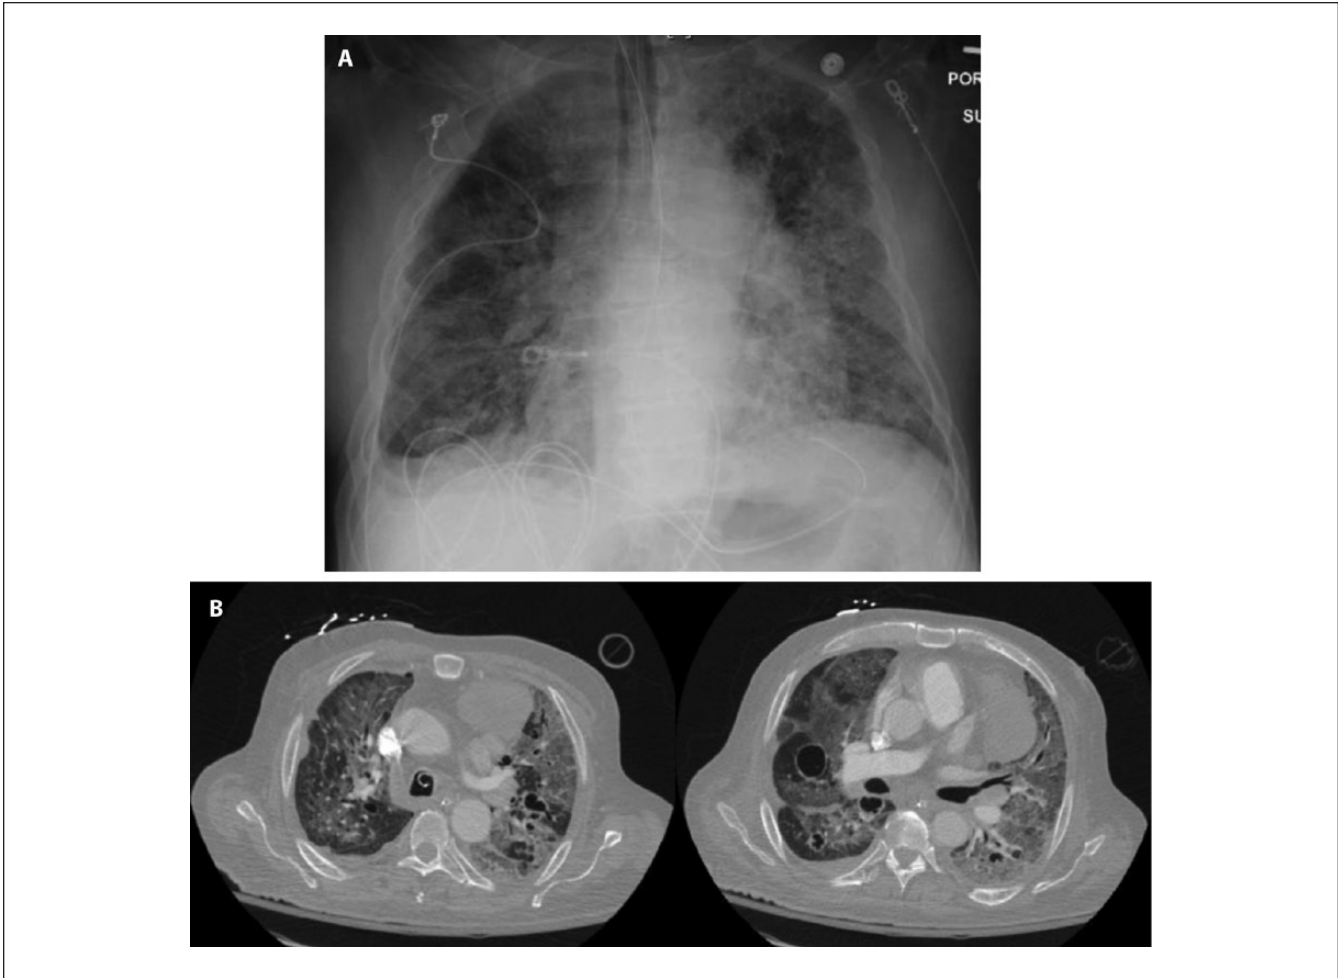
Chest radiographic findings at the time of hospital admission. (A) Chest X-ray showing endotracheal tube and diffuse ground glass opacity and (B) representative cut of chest computed tomography scan showing bilateral ground glass opacity and cavitary lesions.
